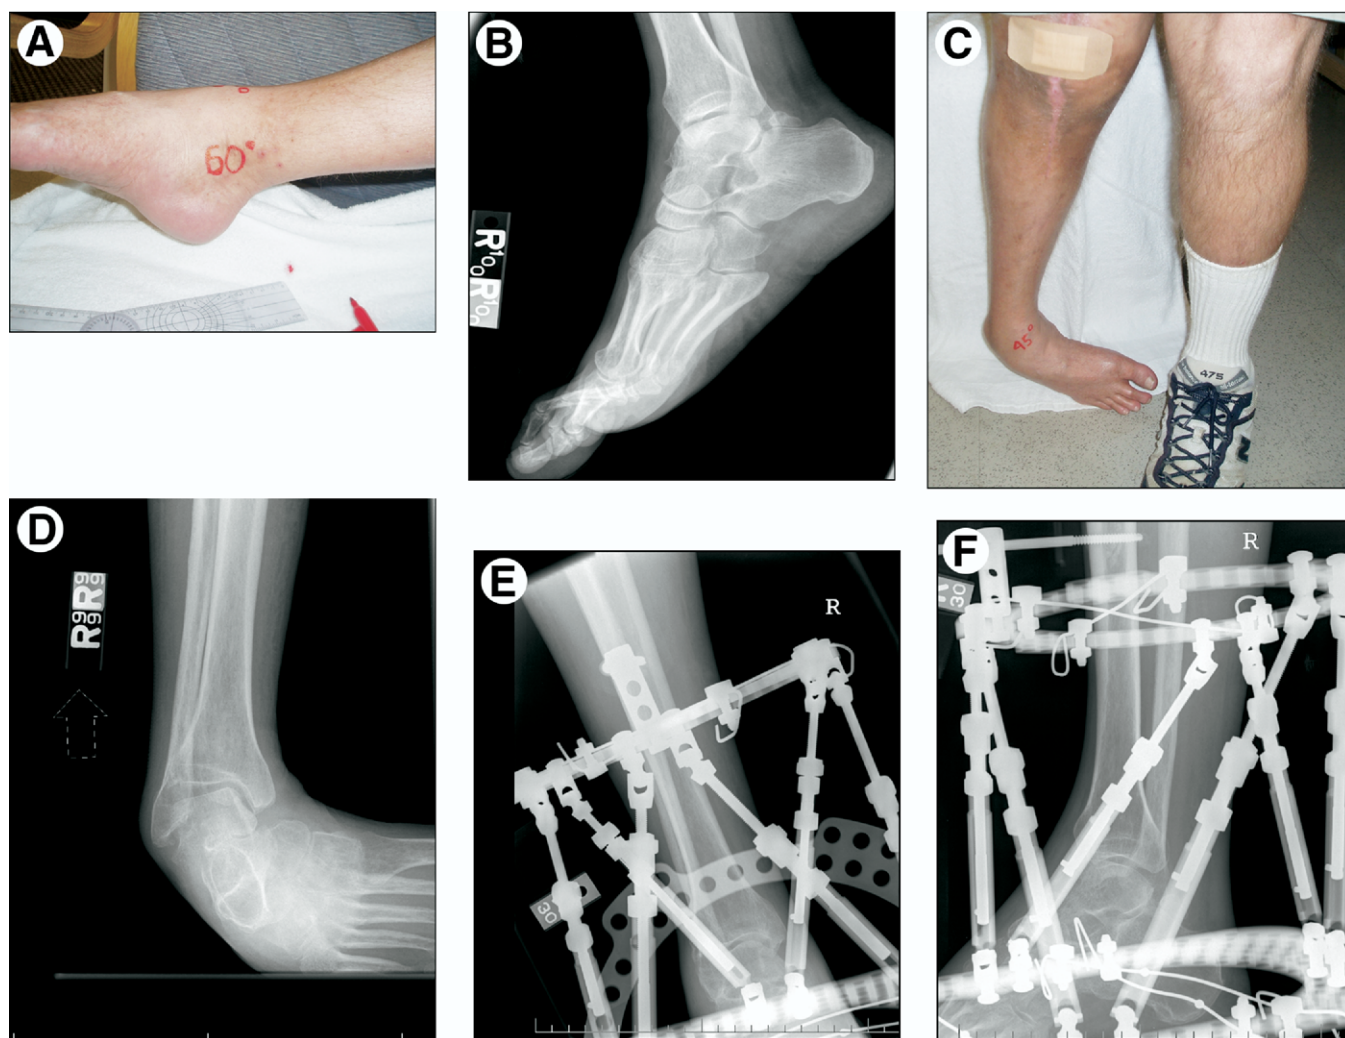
(A-D) AP and lateral clinical pictures and radiographs of a 35-year-old man with fixed equinovarus deformity secondary to iatrogenic peroneal palsy after a total knee replacement. (E and F) Radiographs after treatment using TSF. (Color version of figure is available online.)
